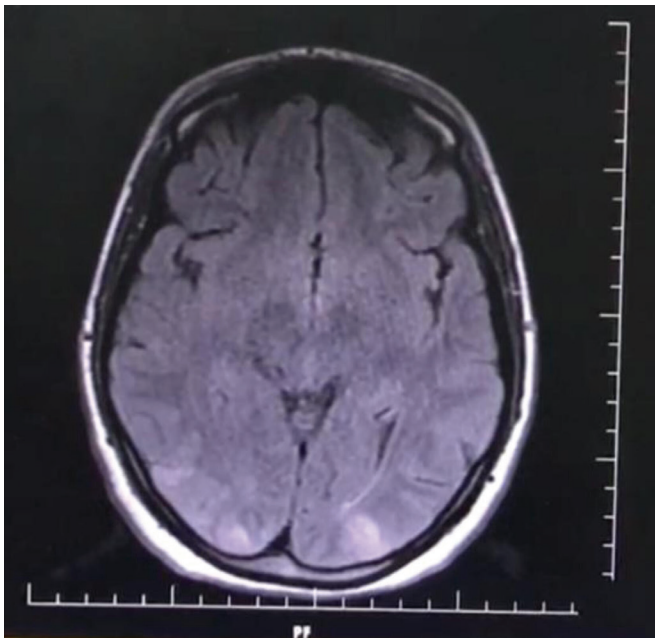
FLAIR scanning, the remarkable appearance of the lesions is detected on cranial magnetic resonance scanning, bilateral asymmetrical cortical and subcortical T2W/FLAIR pathological signal changes are observed in the bilateral posterior parietal and occipital regions
